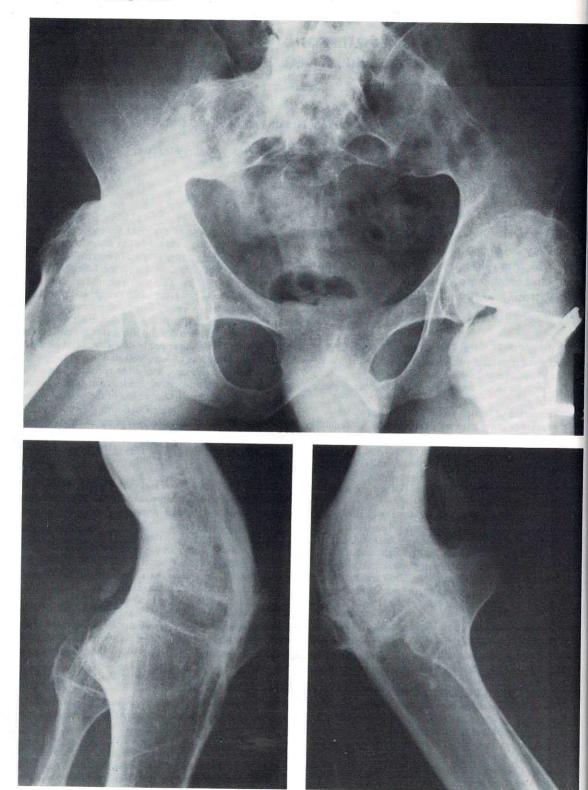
Radiographs of fused hip and knee joints.
